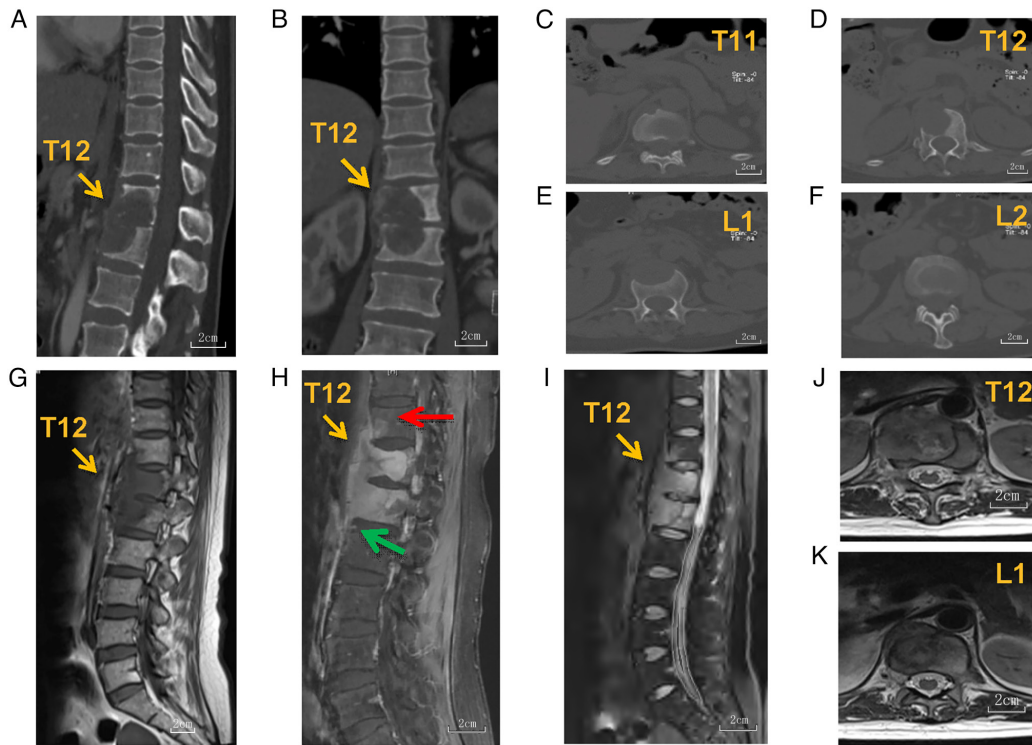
Presentation of the imaging prior to the operation. (A-F) Computed tomography sagittal (A) and coronal (B) reconstruction films revealed an osteolytic, expansile lesion in the spine, with (C) T11, (D) T12, (E) L1 and (F) L2 being invaded. (G-I) On magnetic resonance imaging scans, the lesion was (G) T1-weighted hypointensive and (I) T2-weighted hyperintensive, with edema signals in the normal parts of the vertebrae. (H) The lesion displayed homogeneous enhancement on T1-enhanced films. The lesion invaded the (C and H) anterior, lower corner of T11 (red arrow in H) and (F and H) anterior superior corner of L2 (green arrow in H). (H) A long-flank soft tissue mass was revealed along the anterior T11 to the superior corner of the L2 vertebra. From the images of (J) T12 and (K) L1 planes, the right crus of the diaphragm had a possible involvement with the tumor, whilst the periaortic space stayed uninvaded (scale bars, 2 cm).
